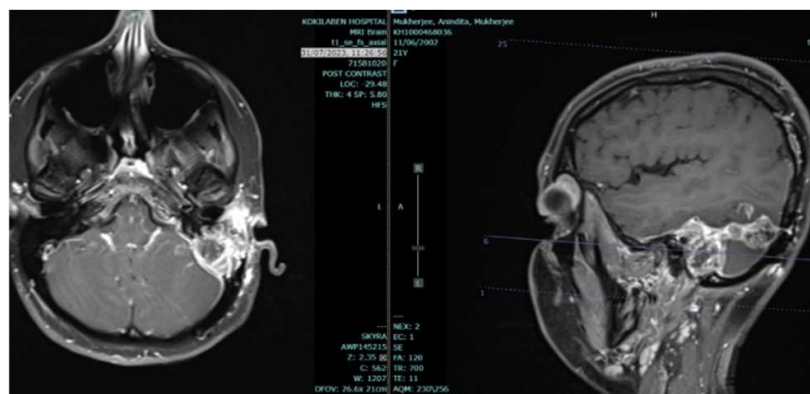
After 1 year MRI a) axial section b) sagittal section showing recurrent left temporal lesion.
